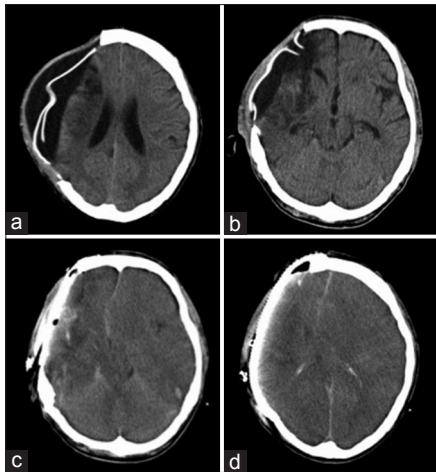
Computed tomography scans in case 1 (a and b) preoperative axial computed tomography scan showing distinct subcutaneous fluid collection and subdural space. (c and d) Postoperative axial computed tomography scan showing whole brain swelling and midline shift
